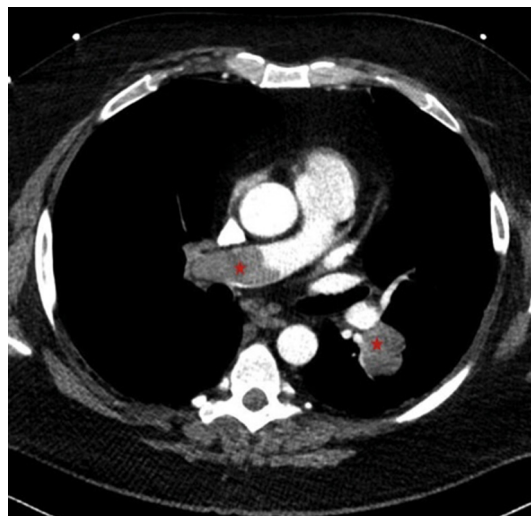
Computer tomography angiography shows bilateral acute PE (red star) in a patient who underwent craniotomy for cranial metastasis removal a few weeks earlier. This patient was also found to have bilateral DVTs in Doppler ultrasound.
